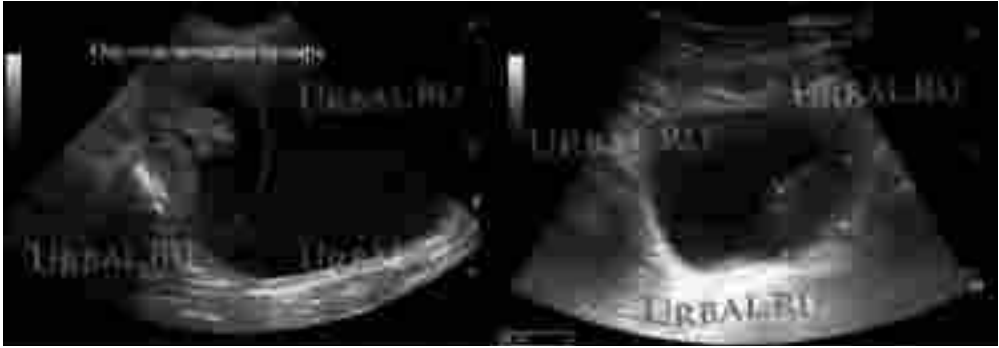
Bladder ultrasound
